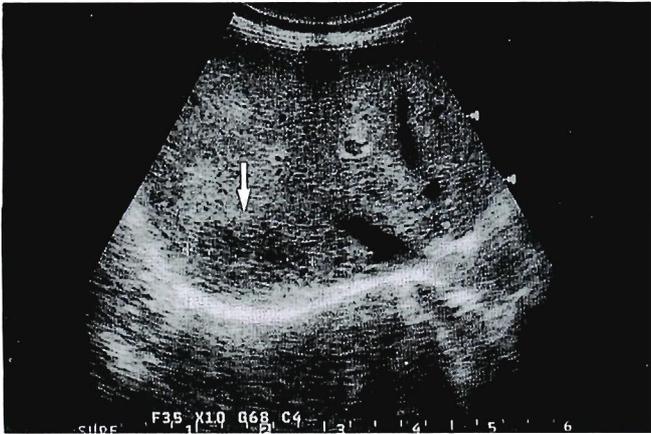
Ultrasonography showing an irregular hypoechoic area in the posterosuperior segment (Case 2).
